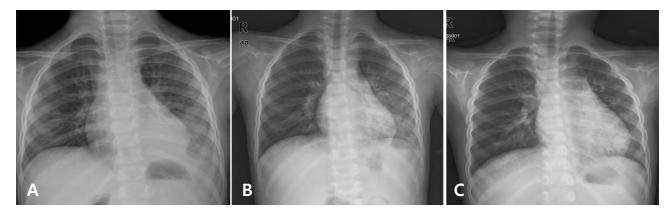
The chest x-ray findings showed haziness at left lower lung field with small amount of pleural effusion on admission (A), decreased infiltration on the 4th hospital day (B), and mild cardiomegaly without change in pulmonary infiltration on the 5th hospital day (C).
